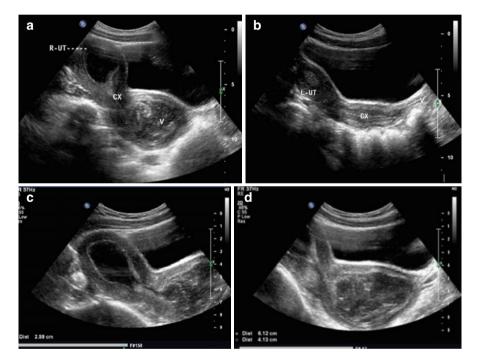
Congenital oblique vaginal syndrome: a 12-year-old patient presenting with severe dysmenorrhea at menarche. Abdominal ultrasound scan shows a double uterus, double cervix, retention of blood in the right uterine cavity and vagina, as well as absence of the right kidney. (a) shows the right uterus and cervix; (b) shows the left uterus and cervix; (c) shows the right uterine cavity with echo-free zone of a thickness of 2.6 cm (due to retention of blood); (d) shows an echo-free zone in the vagina with a size of 6.2×4.1 cm, in which dense dots or strips echo can be seen; (e) shows the left uterine size $(5.0 \times 2.9 \text{ cm})$ with uterine endometrial echo; (f) shows an absence of the right kidney. (g) Compensatory hypertrophy of the left kidney
